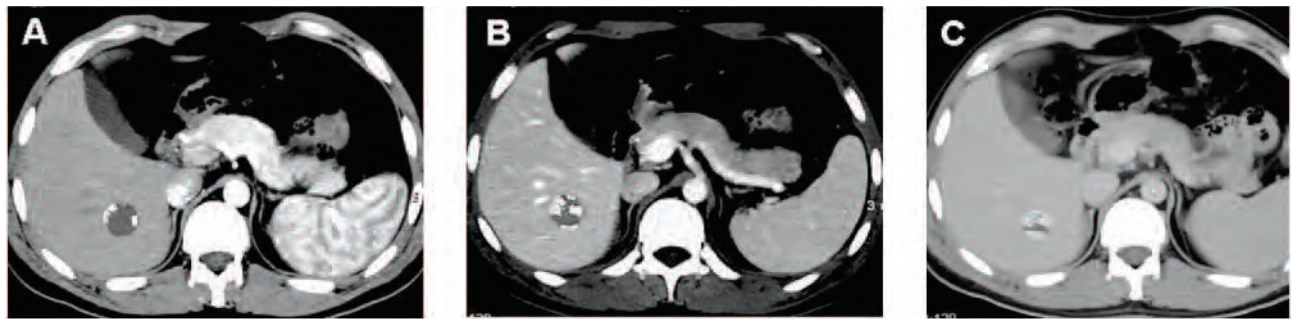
A–C. A 34-year-old female potential living-liver donor. Axial computed tomography images during the arterial (A), venous (B), and delayed (C) phases show typical features of a hemangioma with peripheral nodular enhancement in Figure 10A that increases in a centripetal manner in Figures 10B and 10C
